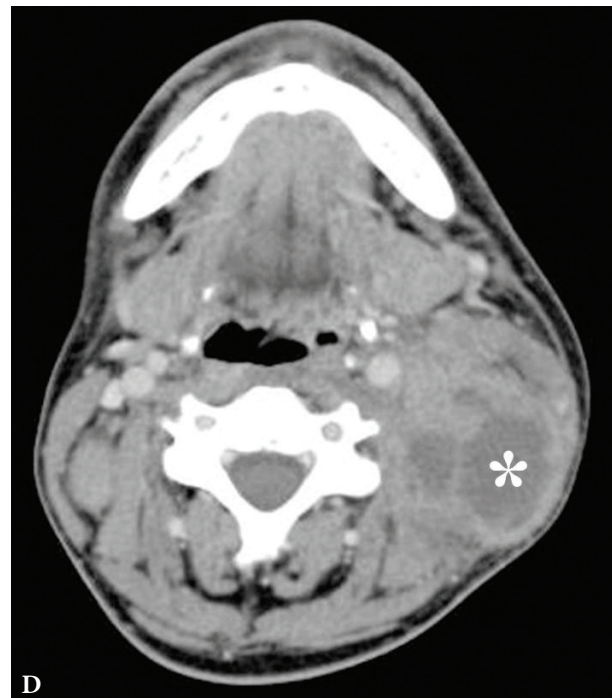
A 24-years-old man with cystic squamous cell carcinoma of the neck (poorly differentiated, which have the most aggressive behavior). Clinical photograph of the patient (A). Transverse gray scale ultrasound of the lower (B) and upper (C) neck shows multicameral lesion with anechoic cystic (asterisks) and heterogenous solid component, presented in the form of irregularly shaped intracystic growths (arrows). Acoustic enhancement artifact is presented. On contrast-enhanced CT images (D, E), the lesion on left side of the neck is multicameral (cameras are marked by asterisks) with solid component accumulating contrast. (Fig 9 continued on the next page.)
